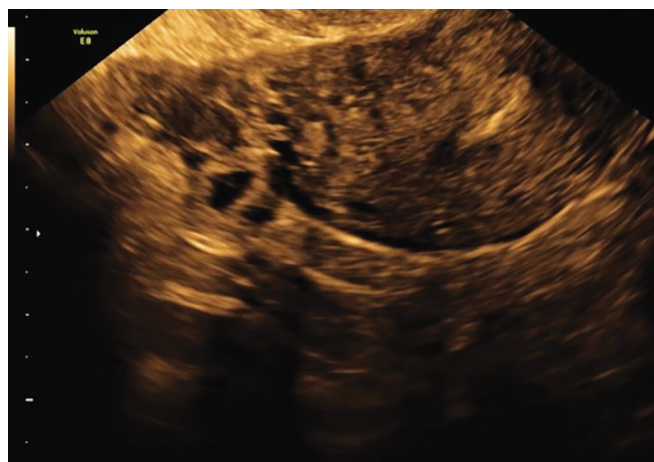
Ultrasound picture of ectopic pregnancy
